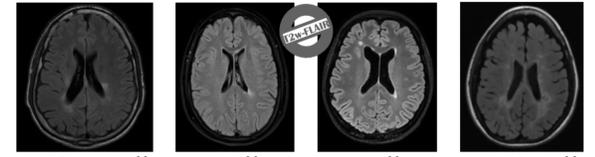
Problem: in MRI acquisition shifts and protocols not standards
